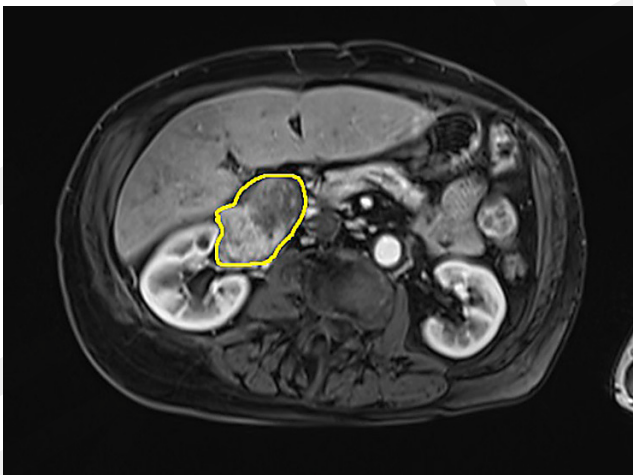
MRI image of the IVC filling thrombus (yellow contour) originating from the right renal vein
